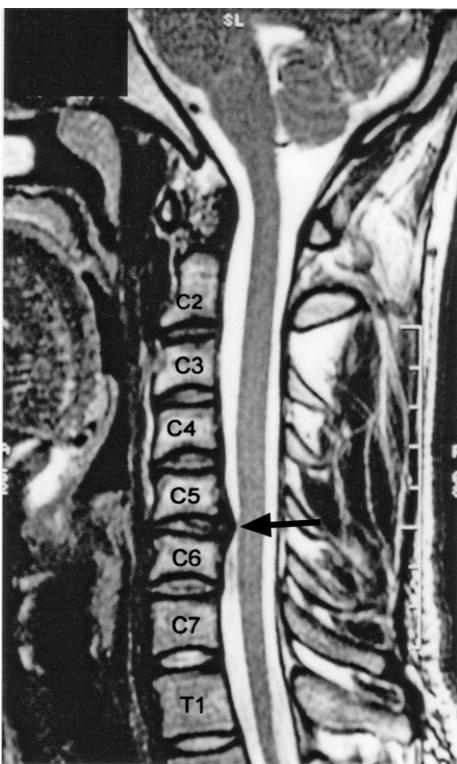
Cervical spine MRI sagittal T2-weighted image. Note the considerable C5–6 posterior disc protrusion (arrow). The protrusion presses upon the pain sensitive anterior part of the dural tube and, in all likelihood, presses upon the recurrent meningeal nerves and blood vessels between the protrusion and dural tube.
